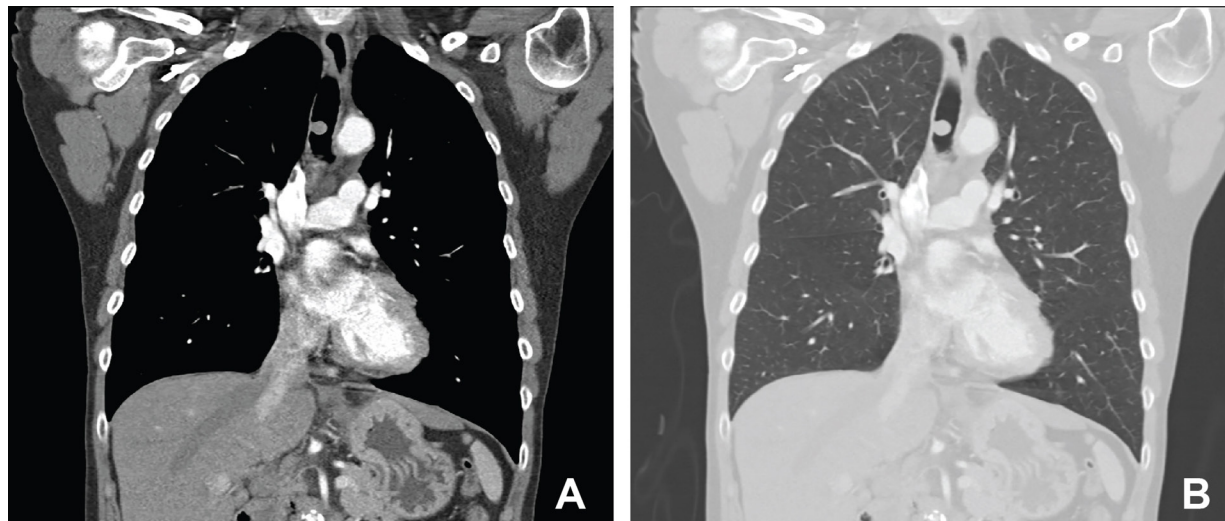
Coronal reconstruction of CT scan of the chest, revealing a large tracheal mass on the mediastinal window (A), and mild emphysema on the lung window (B).
